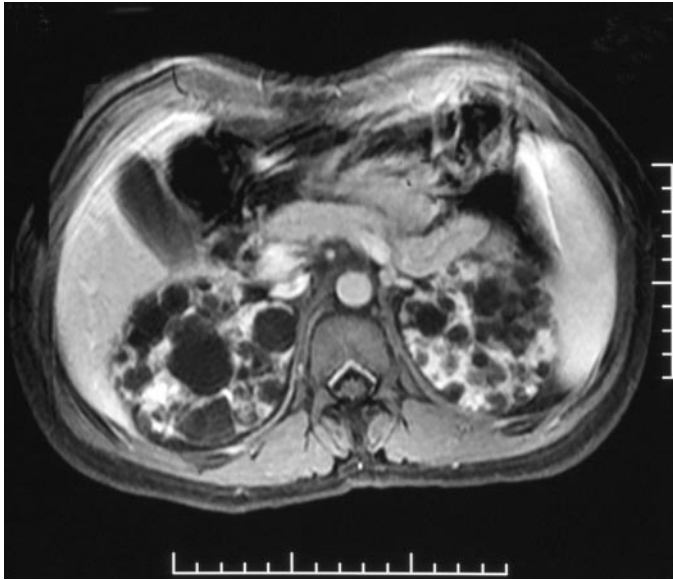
Renal magnetic resonance imaging showing enlarged kidneys (+3 SD) with diffuse bilateral macrocysts suggesting autosomal dominant polycystic kidney phenotype (patient 2).
